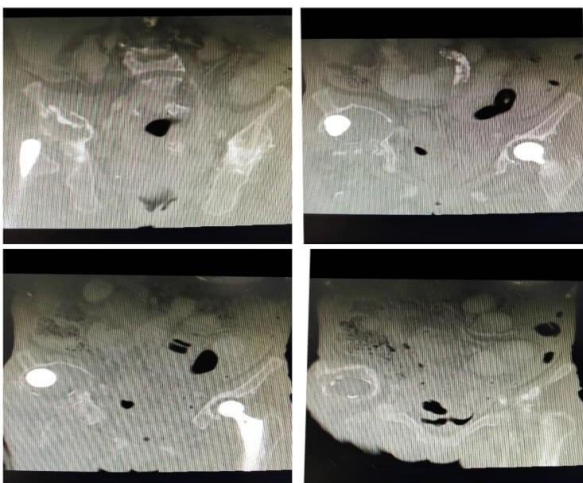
CT Pelvis shows Osteolytic lesion over right acetabular wall and ilium.
